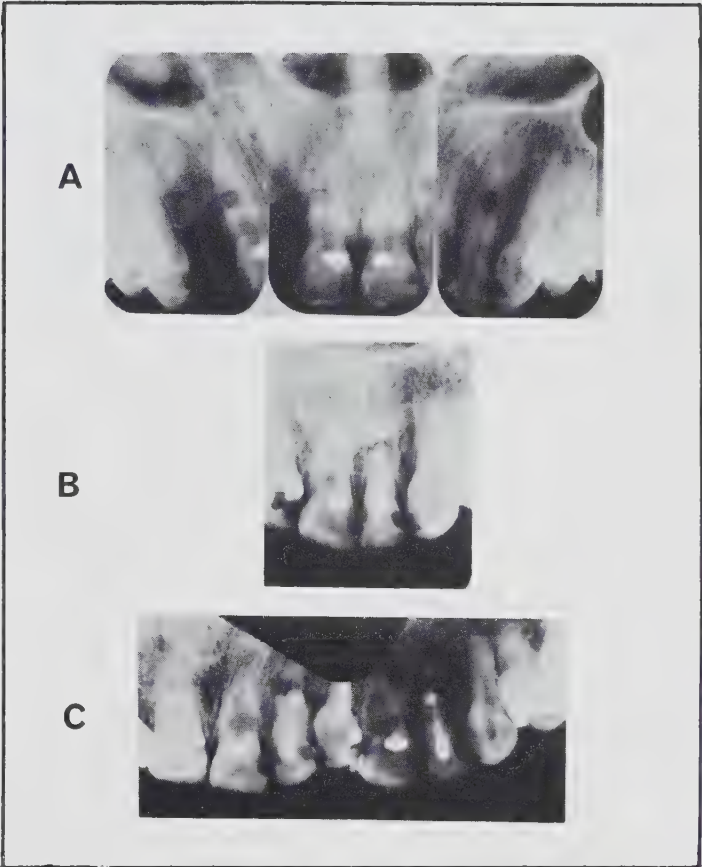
(A). (August 14) — Radiographs show internal resorption of the maxillary right central and left lateral incisor. There is no evidence of internal resorption of the left central incisor. (B). (September 9) — Radiograph shows internal resorption of the left central incisor. (C). (October 27) — Only seven weeks after discovery of the resorption, the lesion had advanced close to the point of perforation. Co-incidentally, the lesion of the left lateral incisor had also advanced.
